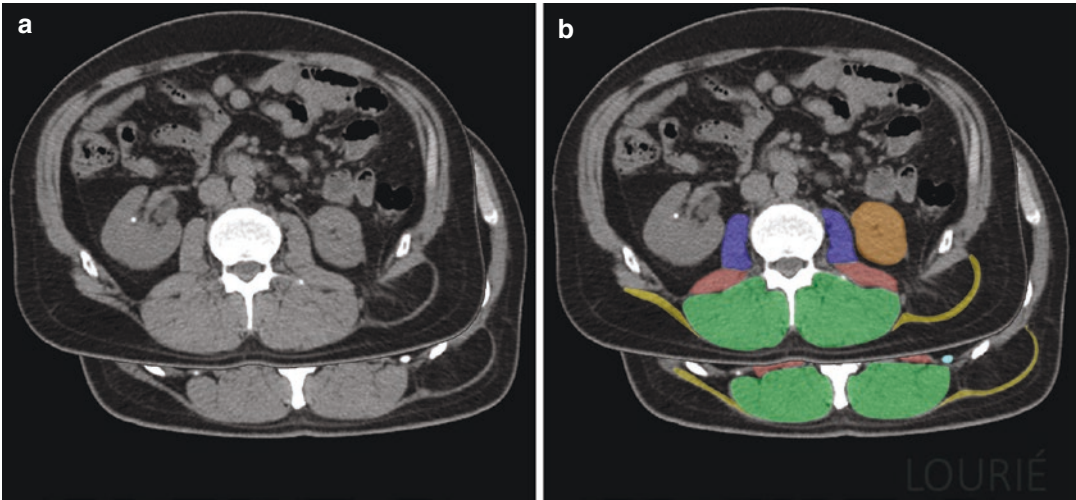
Left-sided Grynfeltt-Lesshaft hernia. (a) Axial Computed Tomography (CT) abdomen cuts (*background slice more cranial*). (b) Same images, colored. Note the pathologic convexity of the left latissimus dorsi muscle (*yellow*) as it arches over the herniated contents (*latissimus balloon sign*) compared to the normal right latissimus
